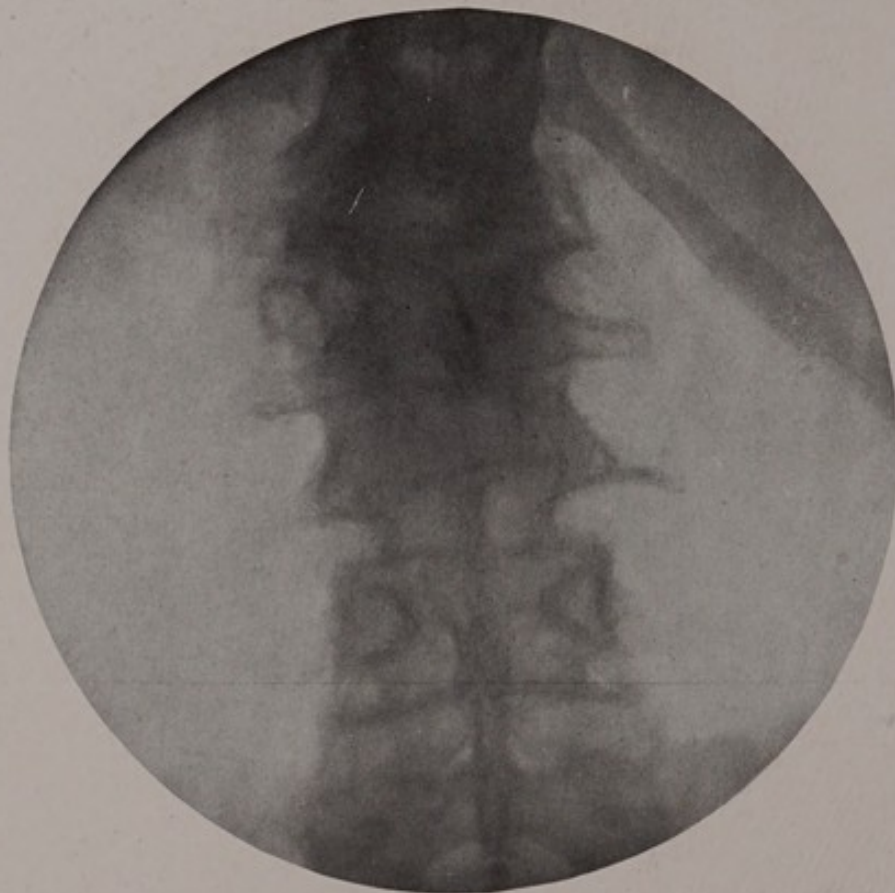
X-ray of fracture of the first and second lumbar vertebræ (N. Y. Neurological Institute).
